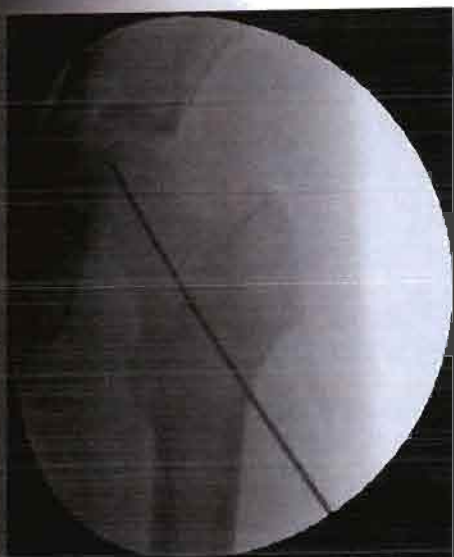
(a, b) Placing of the guide wire into the center of the femoral head under fluoroscopic or CT control
